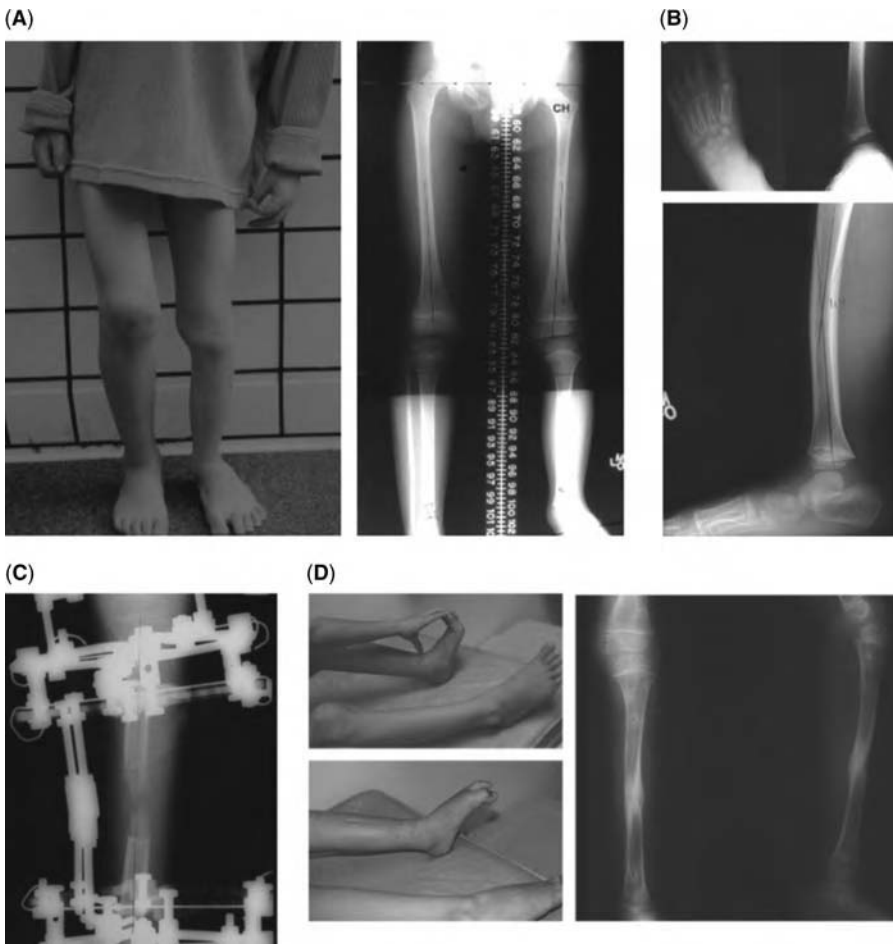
(A) Preoperative photo and radiographs of boy without fibula or coalition and five toes. (B) Preoperative radiographs demonstrating tibial and ankle deformity and five toes. (C) Radiograph during lengthening after correction of tibia valga. (D) Final photos showing ankle ROM and X-rays demonstrating elimination of valgus and procurvatum.
